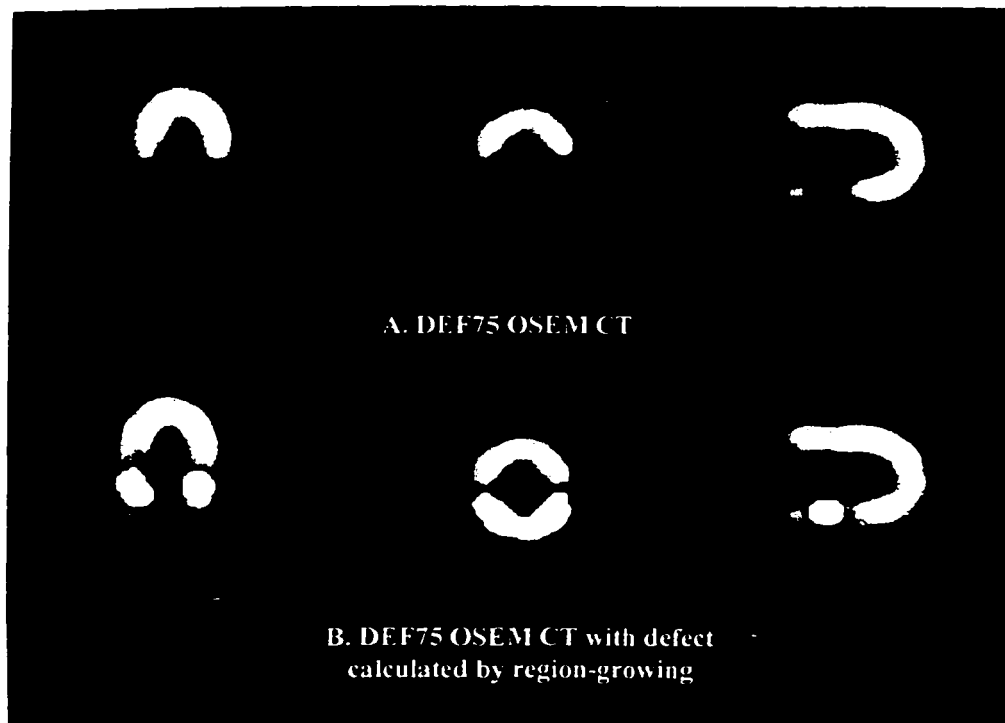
Processed DEF75 images. A. DEF75 OSEM CT images. B. DEF75 OSEM CT with defect calculated by region-growing.
